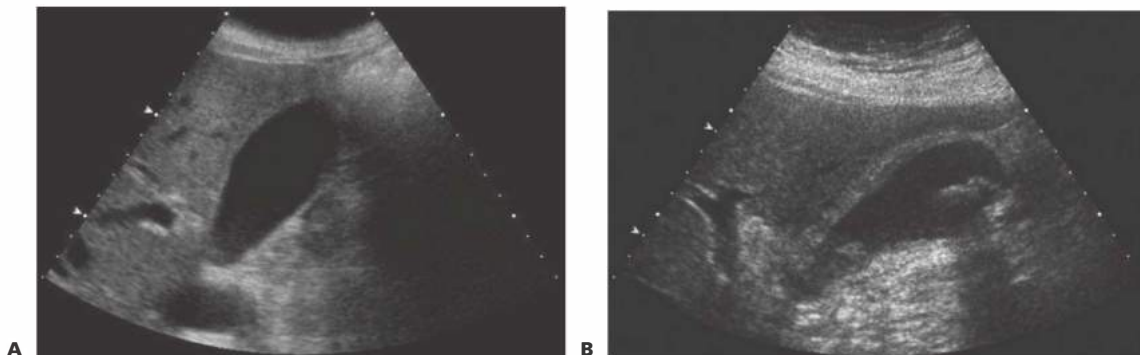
• Gallbladder ultrasound. Figure A demonstrates the normal ultrasound appearance of the gallbladder. In Figure B, the presence of gallstones, thickening of the gallbladder wall, and gallbladder wall edema are suggestive of acute cholecystitis.
